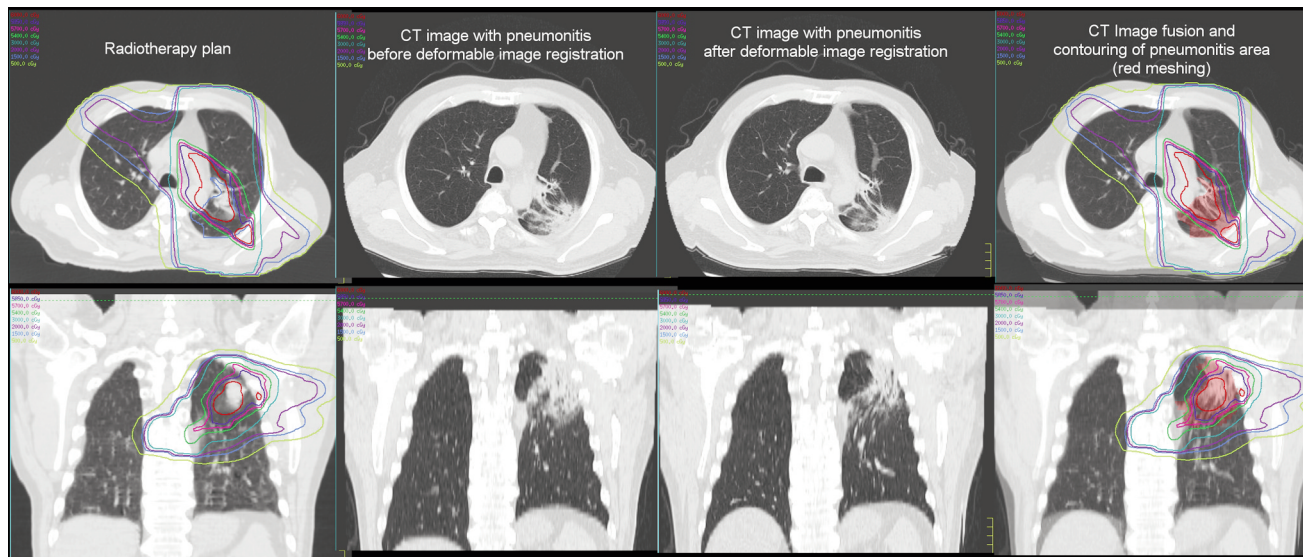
Radiotherapy plan, CT images with pneumonitis before and after deformable image registration, and contoured pneumonitis area.
